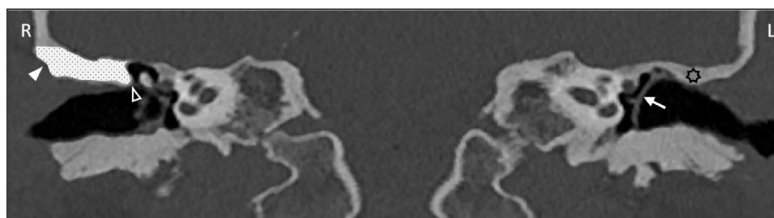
Coronal CT image in the region of the anterior epitympanum, where the labyrinthine segment and proximal tympanic segment of the facial nerves appear as separate structures just posterior to the geniculate ganglion. On the non-operated side (R), the bone lateral to the epitympanum, from the blunted scutum (white unfilled arrowhead) to the outer cortex (white filled arrowhead) is present (highlighted area). On the operated side (L), this bone has been removed, such that the entire epitympanum is visible from the external auditory canal. Osteoneogenesis during the healing phase has caused a slight thickening of the bone at the center of this bony plate (black unfilled 7-point star). A neotympanum of cartilage (white arrow) can be seen extending from the epitympanum to the floor of the external auditory canal.
